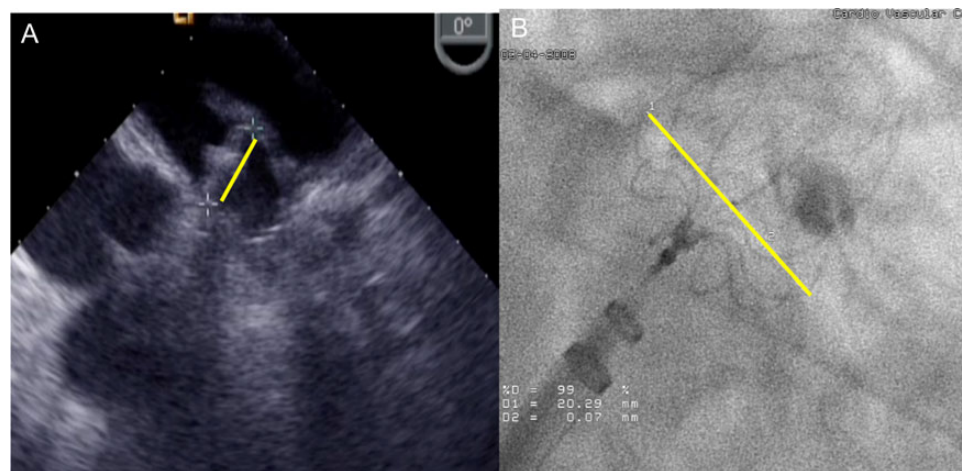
Compression test. For some devices, compression measurement is important. This 24 mm Watchman device is measured on echocardiography as 19.3 mm and angiography as 20.3 mm. This is between the recommended 80–94% compression.
